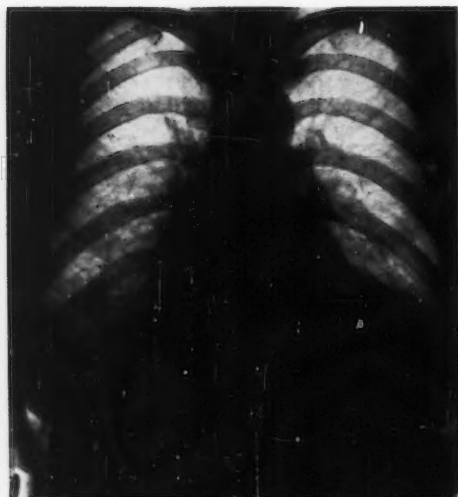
X-ray mother of cases 1 and 2. Slightly dilated globular shaped heart.
